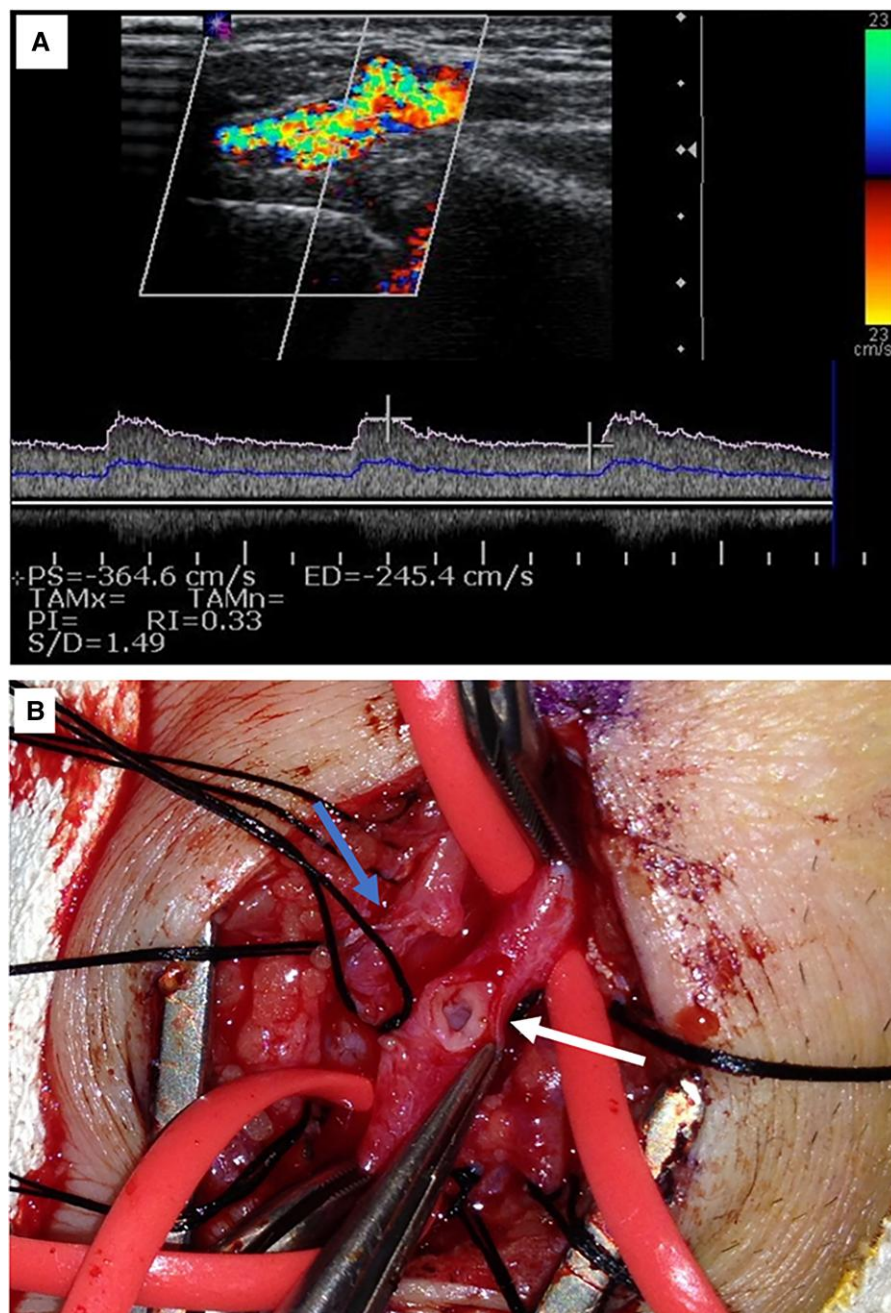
(A) Duplex ultrasonography of the radial artery confirming the presence of an arteriovenous fistula. (B) Operative images showing the arterial (white arrow) and venous (blue arrow) sites of the arteriovenous fistula after its surgical division.
